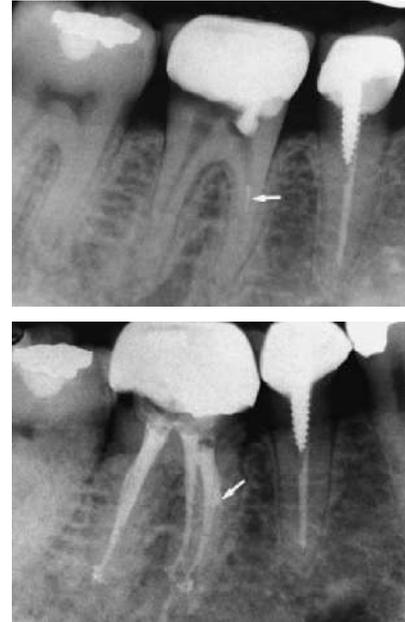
No. A, Arrow showing to a separated rotary instrument in the ML canal of tooth B, Post-obturation radiograph with an arrow showing "tunneling" that was caused with an ultrasonic instrument used to remove the separated instrument. (Courtesy of Dr.MarshallGomes, Lodi, California.)
